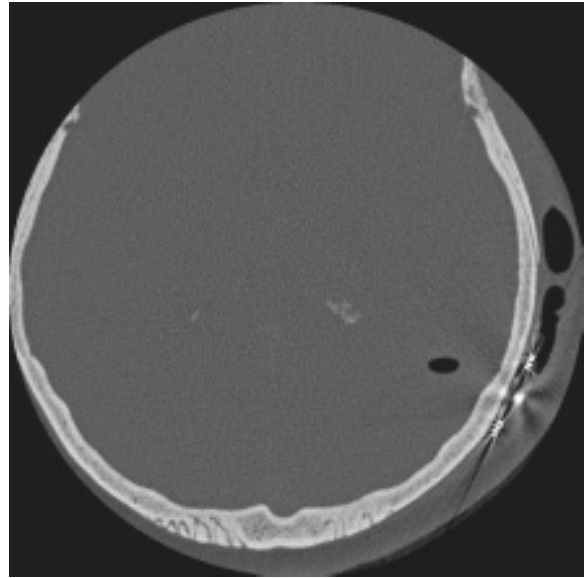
High-resolution CT scan axial cut showing the extracranial soft tissue free air as well as intra-parenchymal pneumocephalus.
